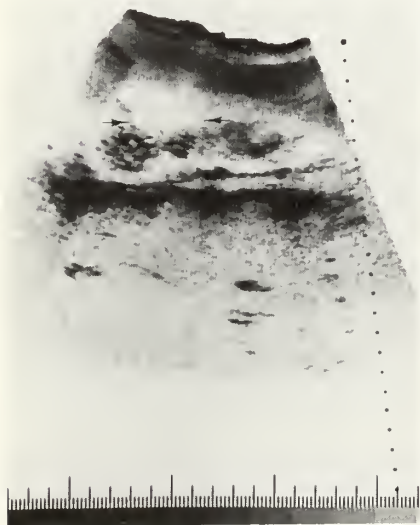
Ultrasound shows a sonolucent mass (arrows) consistent with a cyst.
